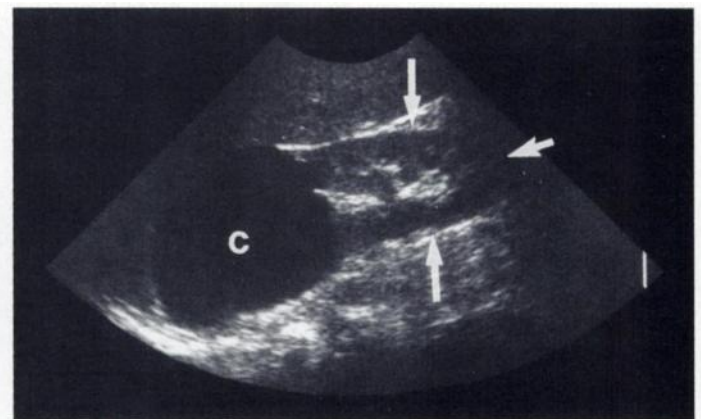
Right renal longitudinal sonogram demonstrates $7.5 \times 8.6 \times 8.7$ cm round, anechoic structure at upper pole that has features characteristic of benign simple cyst (c). Normal kidney (arrows).
